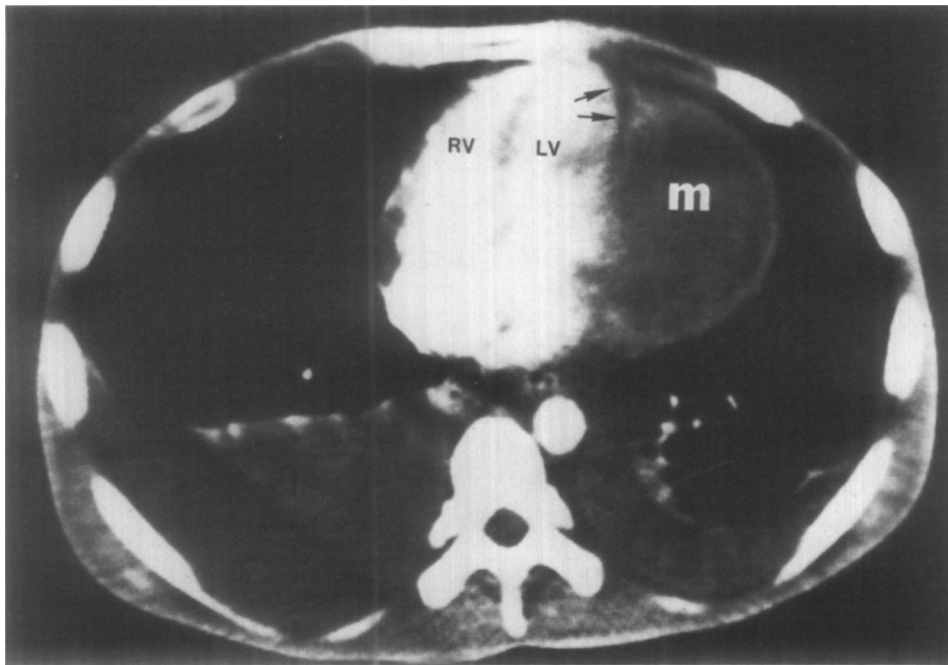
CT scan showing a 1 cm thick axial slice from a series of rapid sequence slices through the heart. A nonenhancing mass lesion of low density (20 HN units) is seen. Note the layer of epicardial fat (arrows) between the mass and the heart anteriorly. Bilateral pleural effusions are also present. *LV* = left ventricle; *m* = mass; *RV* = right ventricle.
